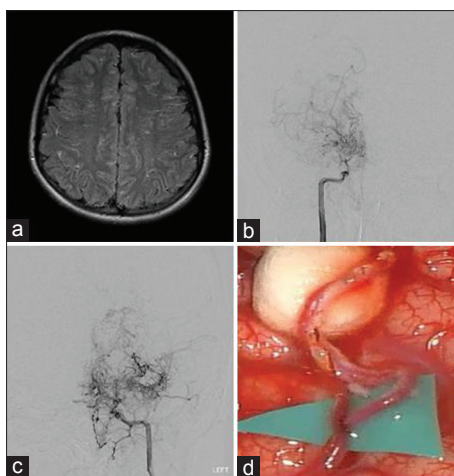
A representative case. Imaging studies of a representative case. (a) Initial brain magnetic resonance imaging showed multiple T2 high signal intensities on deep white matter of the left posterior watershed zone, suggesting previous ischemic insults. (b) Preoperative right internal carotid artery (ICA) angiography showed occlusion of the distal ICA and also steno-occlusive changes on the anterior cerebral artery (ACA), middle cerebral artery (MCA). Marked moyamoya vessels are noted. (c) Preoperative left ICA angiography showed occluded distal ICA like the right side, and severely narrowed ACA, MCA. Characteristic moyamoya vessels are noted on the base of the brain. (d) An intraoperative photograph of the patient showing successful superficial temporal artery-MCA end to side anastomosis
